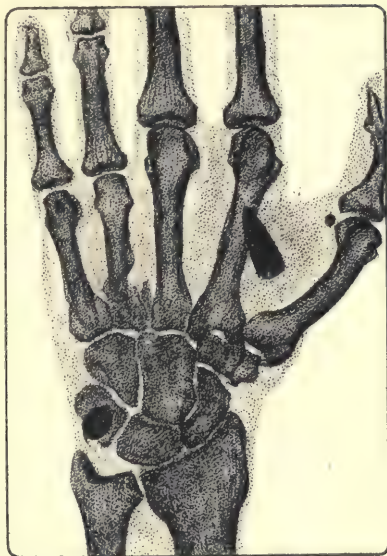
Radiograph of the right hand, seen from its palmar surface. A German bullet projects at the level of the first interosseous space. This man was wounded by a machine gun and a bullet had already been extracted from the front part. He never suspected the presence of the second projectile which has probably entered through the same orifice as the first to which no doubt was due the fracture of the fourth metacarpal. The appearance of the pisiform bone should be noted as it could easily be taken at a first glance for a shrapnel bullet. The sesamoid of the thumb should also be noted and also that of the fifth metacarpal seen through the head of that bone.
